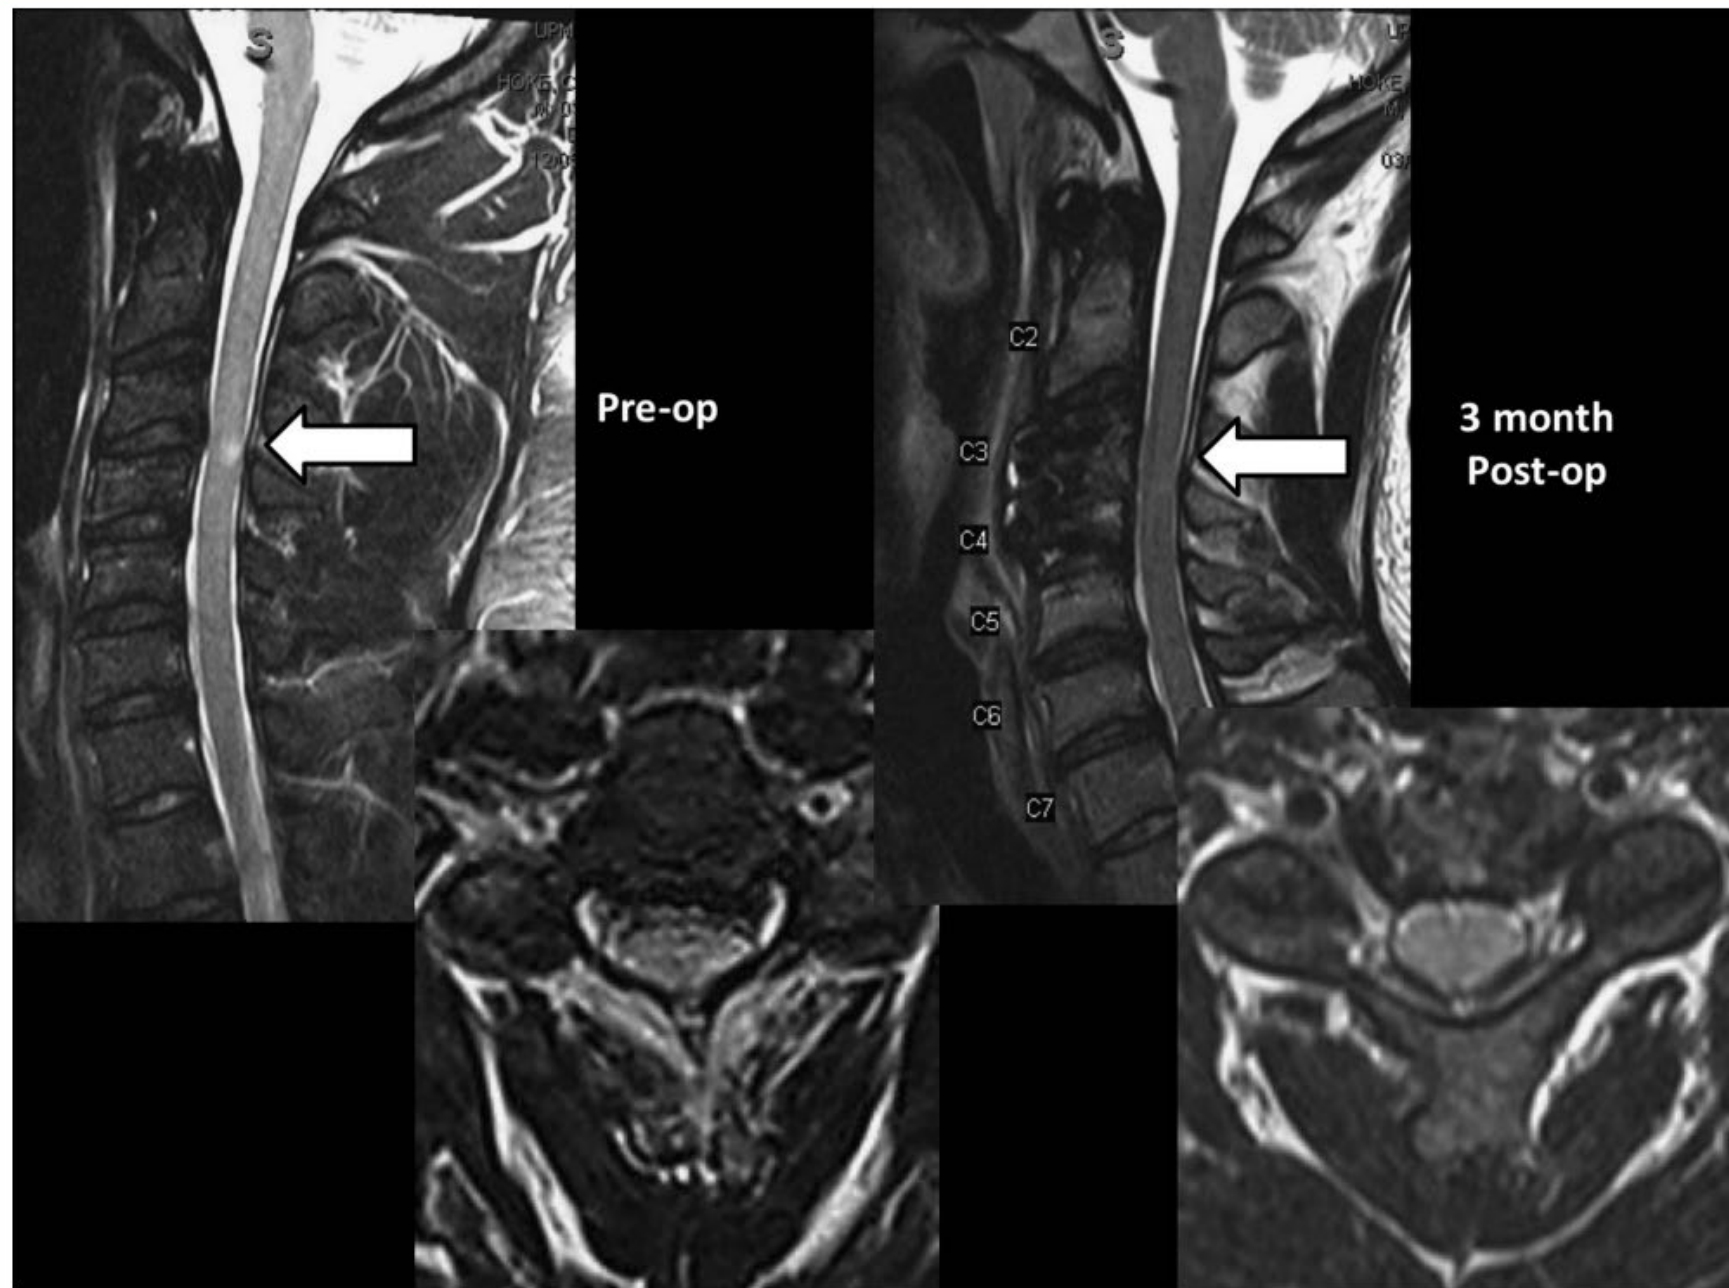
Patient 7 showing both sagittal and axial magnetic resonance images preoperatively and 3 months postoperatively. The arrows point to the hyperintensity cord changes at the C3-4 level preoperatively and resolution of these changes at 3 months postoperatively.
